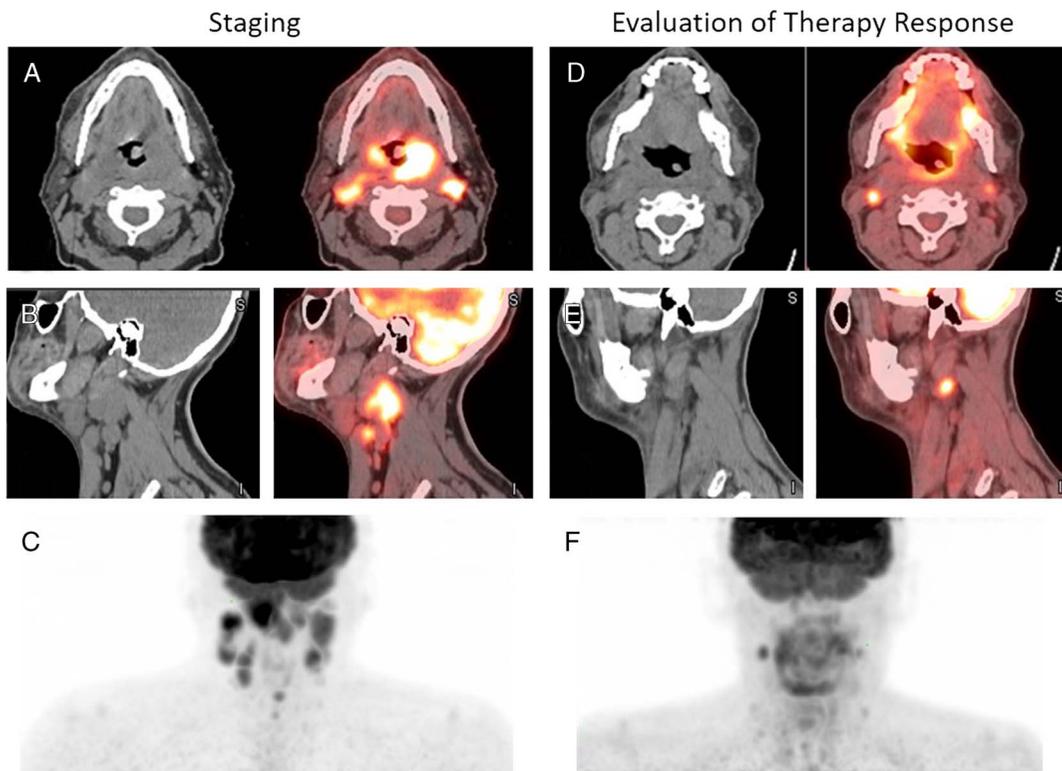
Therapy response—partial metabolic response. A 54-year-old man with a diagnosis of stage T3N2cM0, p16 + poorly differentiated left tonsillar SCC, treated with CRT (A dose of 70 Gy was delivered in 35 fractions of 2 Gy each with concomitant weekly cisplatin). Axial CT and PET/CT fused images (A) showed a large FDG-avid left tonsillar primary tumor (SUV_{max}, 14.6) and bilateral FDG-avid level II lymph nodes; sagittal CT and PET/CT fused images (B) showed level II and III intensely FDG-avid lymph nodes. MIP images (C) showed primary tumor with regional metastatic lymph nodes. Therapy response was evaluated with FDG PET/CT, 3 months after completing CRT. There is resolution of previously seen FDG-avid left tonsillar mass in axial CT and PET/CT fused images (D) and persistent bilateral level II lymph nodes in axial (D) and sagittal CT and PET/CT fused images (E). MIP images (F) showed persistent bilateral level II lymph nodes after CRT. The patient underwent bilateral neck dissection, 1 lymph node (white arrow) that left level II lymph node was found metastatic out of 32 lymph nodes.
